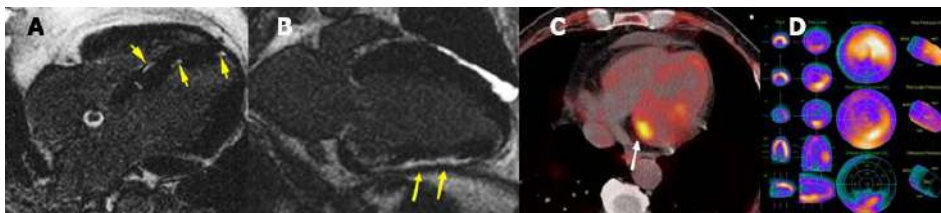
(A) Patchy LGE distribution in the septum (arrows) and (B) subepicardial LGE (arrows) in a patient with sarcoidosis. (C) 18F-FDG uptake in a patient with sarcoidosis (arrow). (D) Perfusion-metabolism mismatch in a patient with sarcoidosis (perfusion defect in the upper image, metabolism uptake in the mid image, and mismatch in the lower image).
